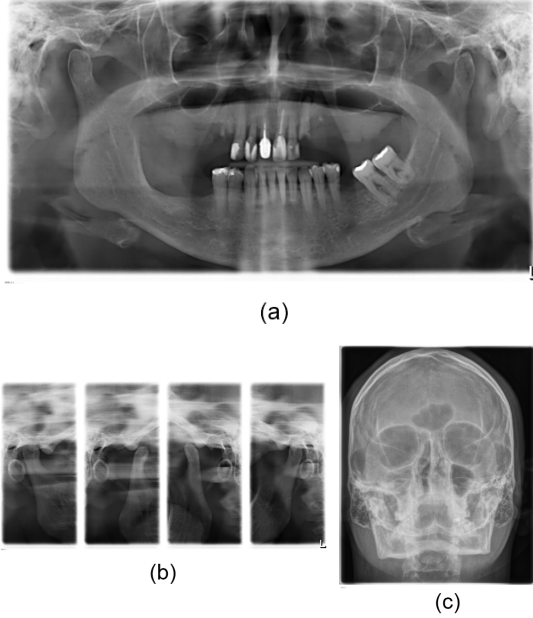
Examples of images removed after visual analysis: (a) The image is labeled as 6 years old, but does not show deciduous teeth, indicating possible inconsistency; (b) radiograph without adequate coverage of the oral and maxillofacial region; (c) blurred head radiograph, without highlighting the oral and maxillary region;
